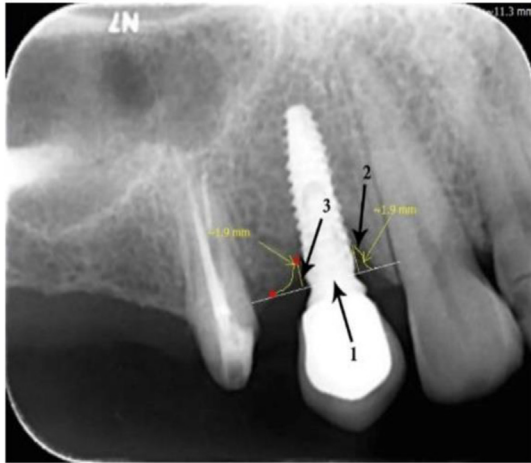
Intraoral periapical radiograph showing; measurement of marginal bone level (3) from the reference line (1) using SCANORA intraoral image Tool.
